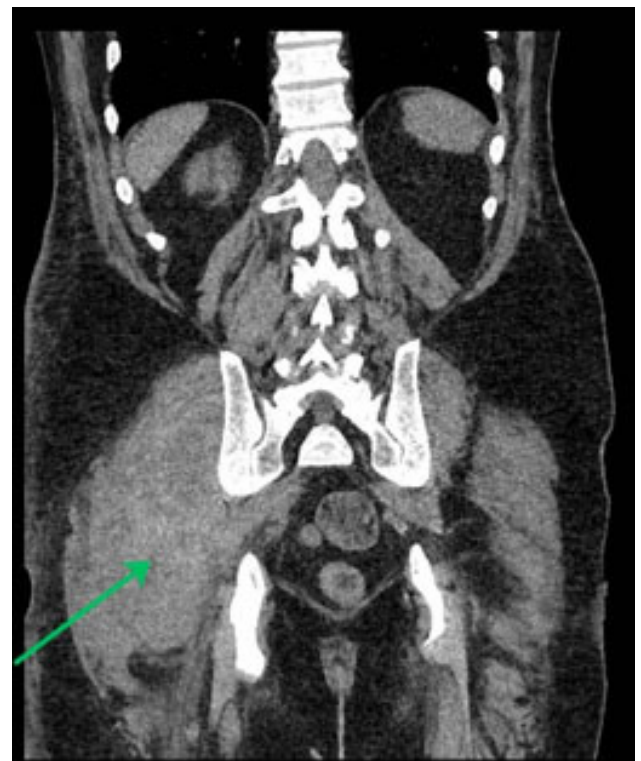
Preoperative CT scan in the coronal plane demonstrating the right gluteal hematoma (green arrow).
